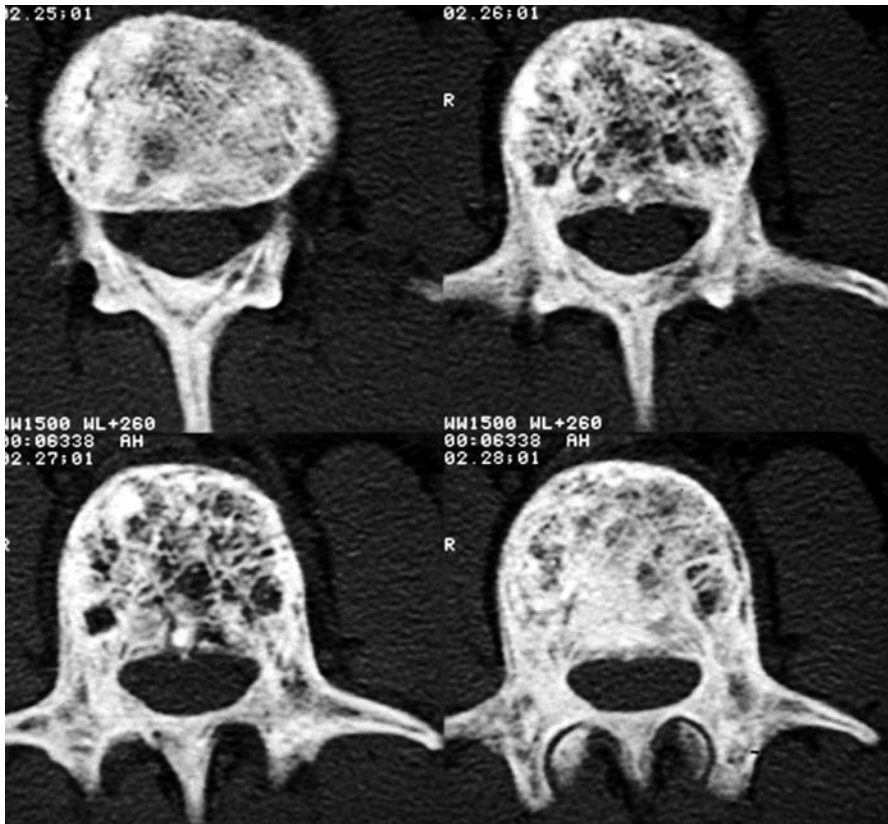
Morbus Paget in area of lumbar spine (CT). Note the altered structure of the trabecular bone. Significant narrowing of the vertebral canal is evident in lower right.
